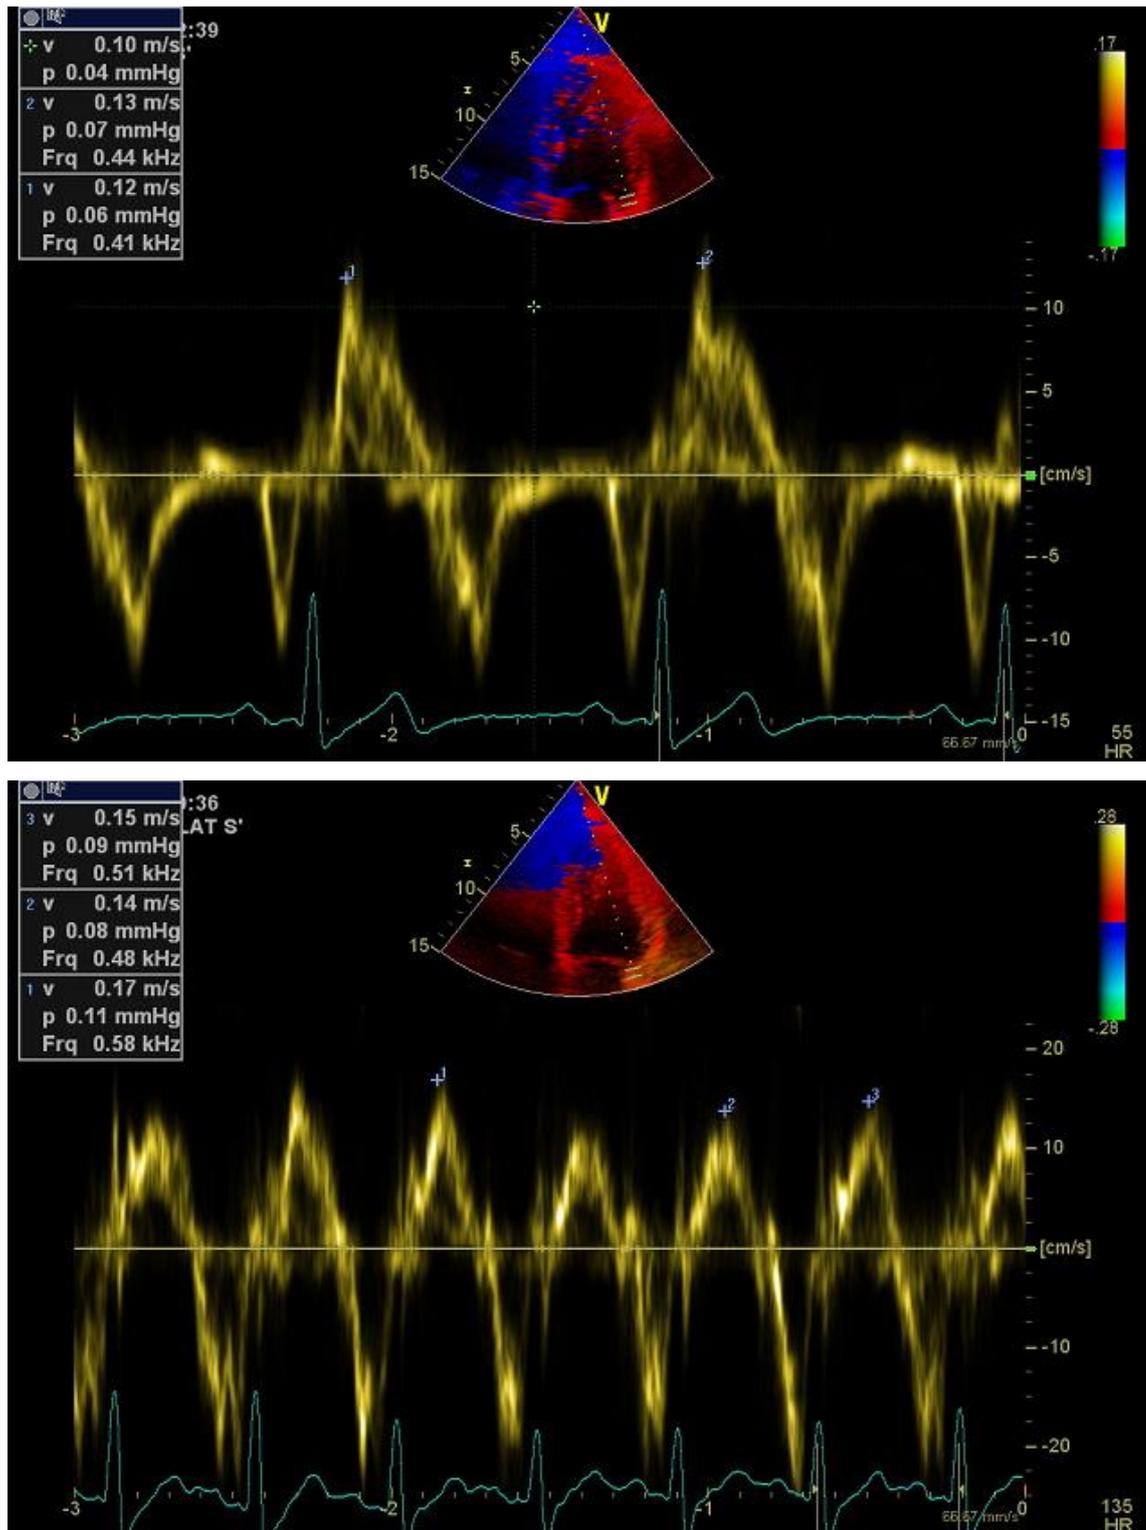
Spectral tissue Doppler at rest (top) and peak exercise (bottom) obtained from the lateral basal segment demonstrating an increase in systolic longitudinal function
